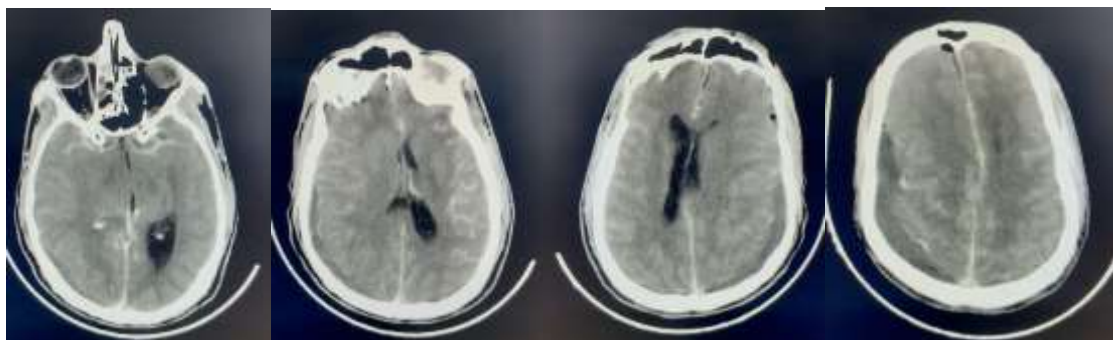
Baseline brain computed tomography (Day 0)
